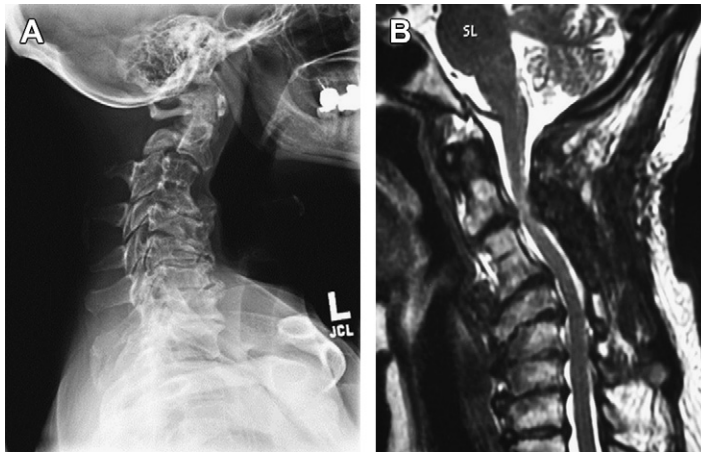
Case example of semirigid deformity that was treated with Smith-Petersen osteotomy (SPO) and cobalt chromium rods. (A) Preoperative lateral radiograph showing cervical kyphosis. (B) Preoperative sagittal MRI showing spinal stenosis.
